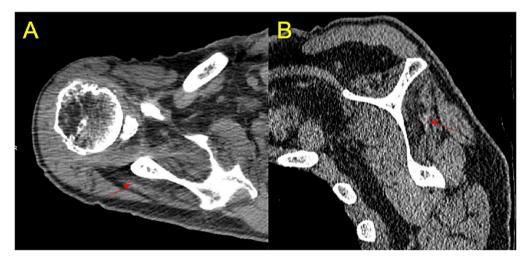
CT images demonstrating Goutallier Grade 4 fatty infiltration of the infraspinatus muscle on (A) axial and (B) sagittal views
